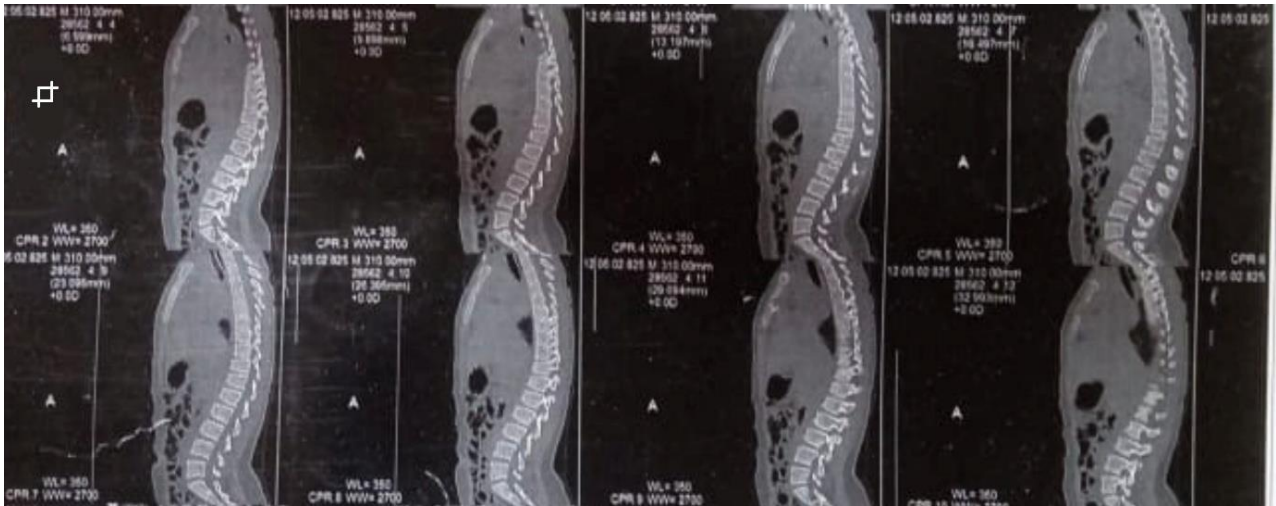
CT scan of the thoracolumbar spine at diagnosis, showing signs of thoracolumbar Scheuermann's disease
